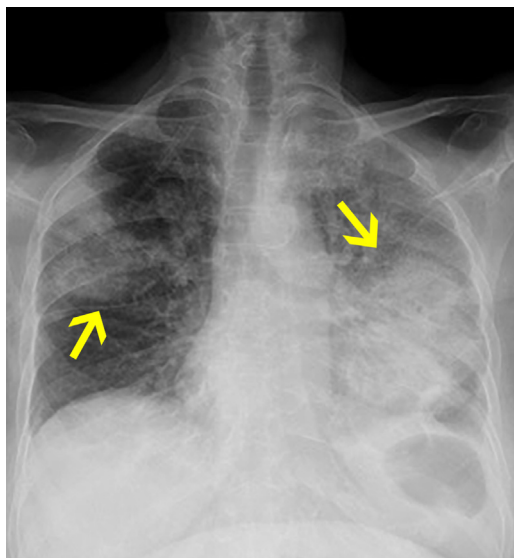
Legionella* pneumonia. Anteroposterior chest radiograph shows bilateral dense and poorly defined "rounded" consolidations in the right upper and left lower lobes (arrows). Community-acquired *Legionella pneumophila* pneumonia was diagnosed.
